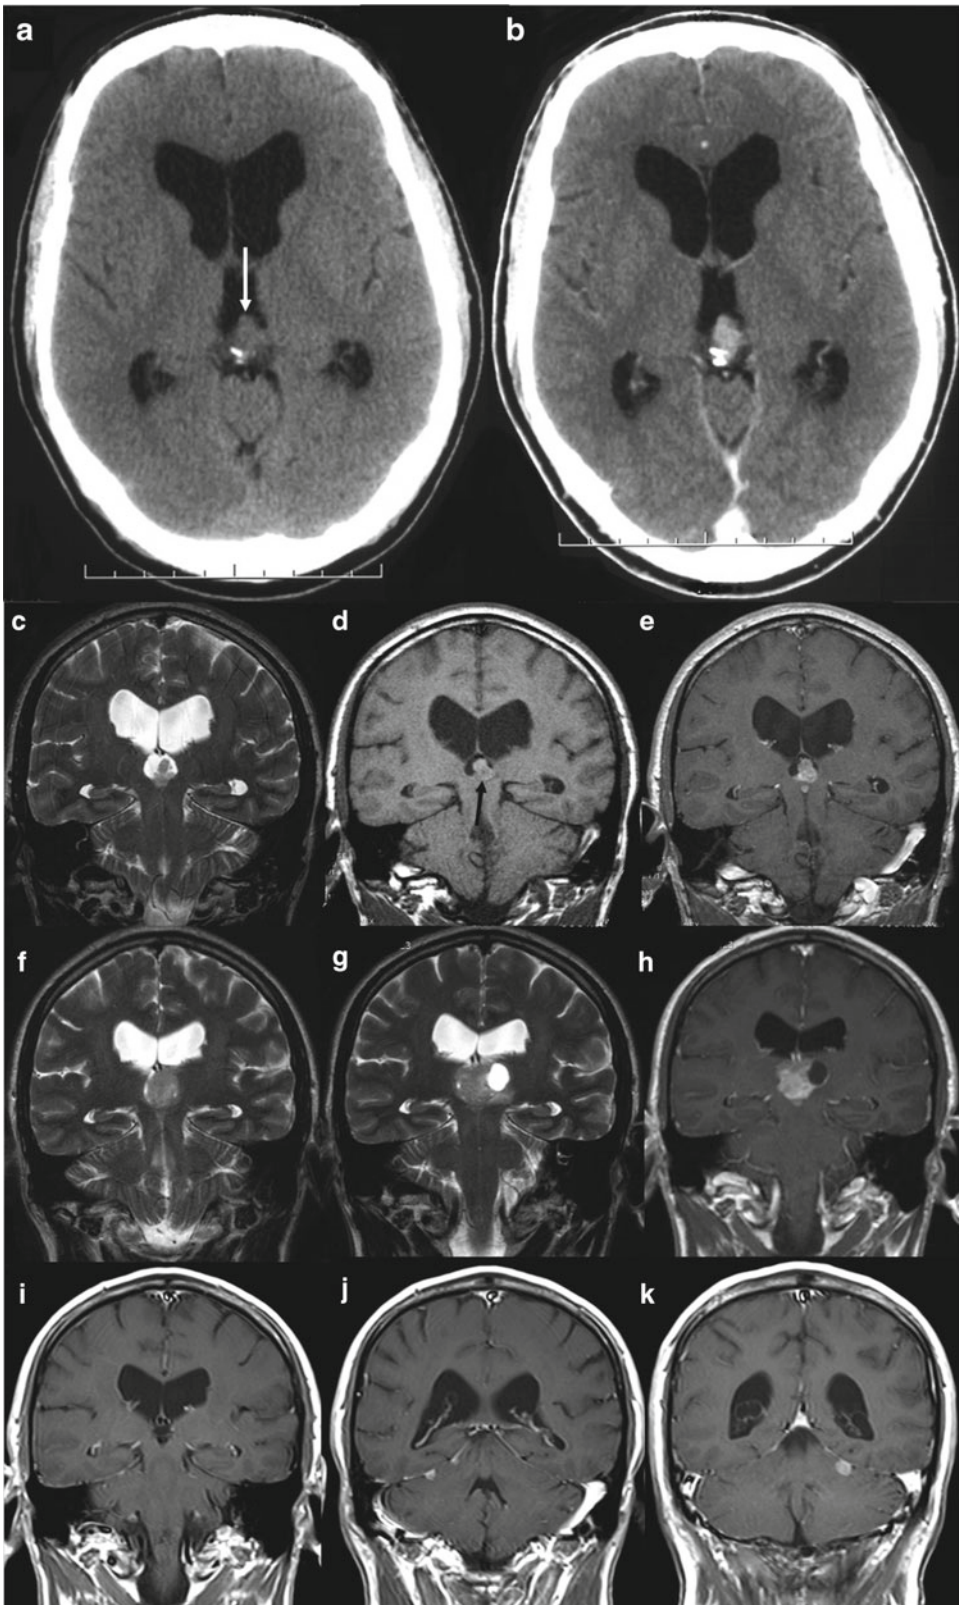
Computed tomography (CT) and magnetic resonance (MR) imaging of the brain of the patient reported
